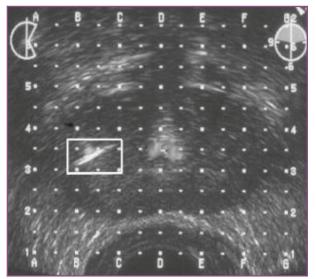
Seed Insertion. Needles containing the radioactive seeds are inserted through the template grid and perineal skin into the prostate and visualized on the ultrasound monitor.
